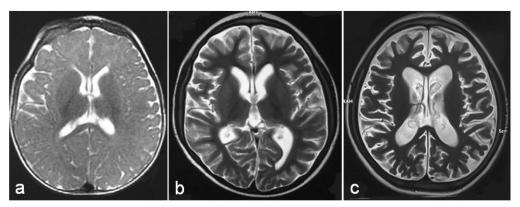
MRI brain T2W images: No abnormality detected before the AE (at seven months) (a). Prominent cortical and white matter atrophy, with marked ventricular dilatation and involvement of the basal ganglia three weeks after the onset of AE (b). More advanced cerebral atrophy was seen seven months after the onset of AE (c).
